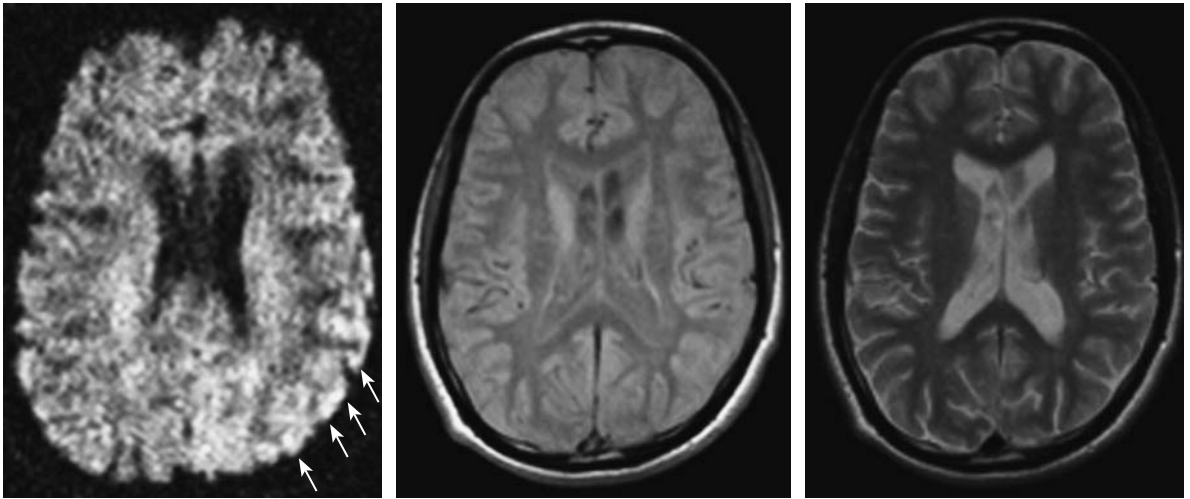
Patient with hemiplegic migraine. *Left*, diffusion weighted MRI during migraine attack with severe right hemiparesis. Note the slight diffusion changes in the left temporal cortex suggesting ischemia. *Middle and right*, follow-up MRI (proton-density- and T2-weighted) 1 year after migraine attack show no structural changes in the left temporal cortex. Clinically the patient recovered completely. (Courtesy of Prof. VON KUMMER)
